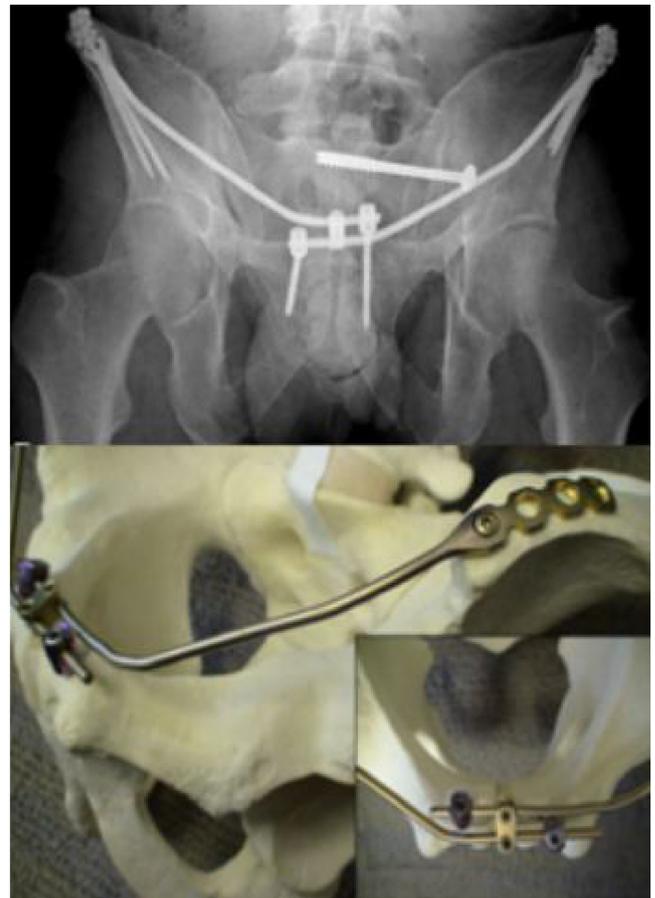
Radiograph and pelvis model demonstrate placement of Pelvic Bridge. A rod-plate construct spans the iliac crest to the contralateral superior pubic rami, and utilizes pedicle screw fixation in the pubic rami and a rod-to-rod connector midline.
